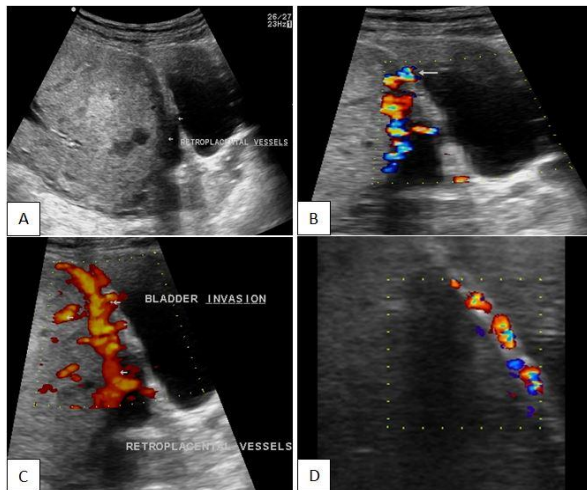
(A) USG showing sonolucentretro placental vessels; (B) Colour Doppler showing increased retro placental vascularity with vessels entering adjoining urinary bladder wall; (C) Power Doppler increased retro placental vascularity with vessels entering adjoining urinary bladder wall suggestive of bladder invasion; (D) Colour doppler on linear probe showing vascularity in urinary bladder wall suggestive of bladder invasion.
